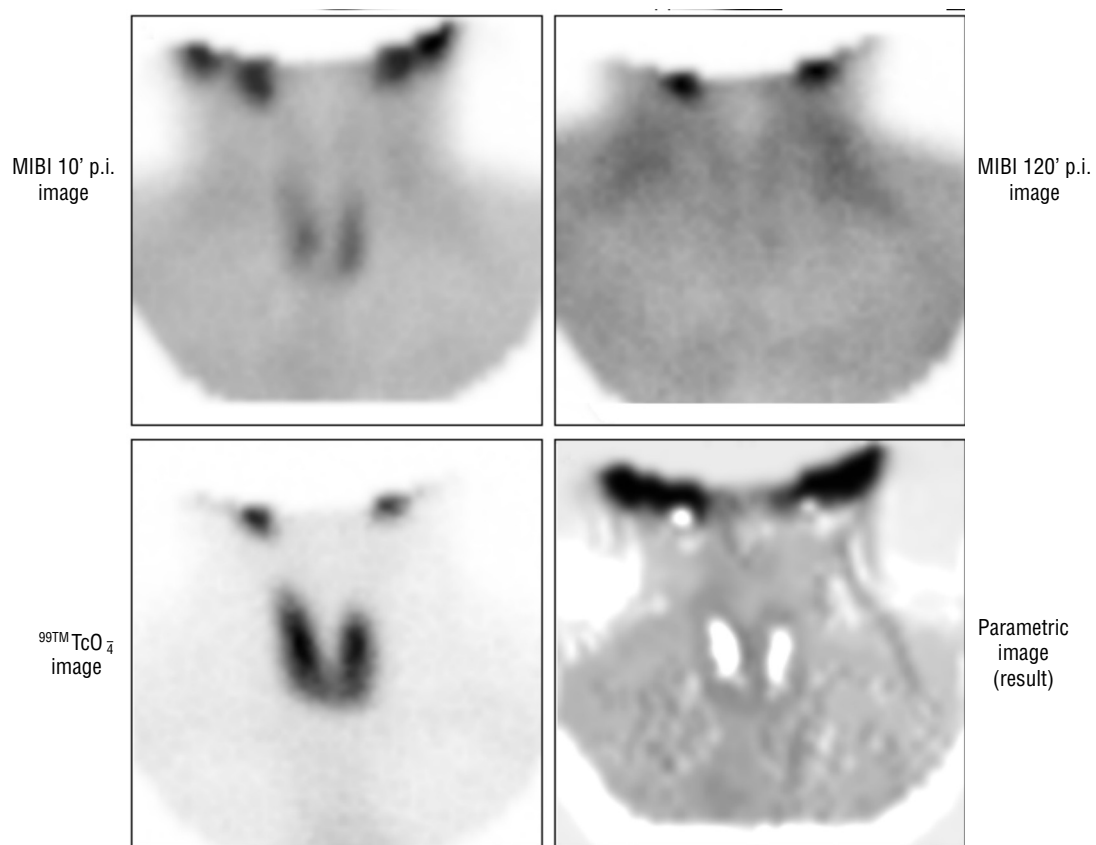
Planar neck scintigrams and the parametric image generated by ANN in a patient without parathyroid adenoma.
